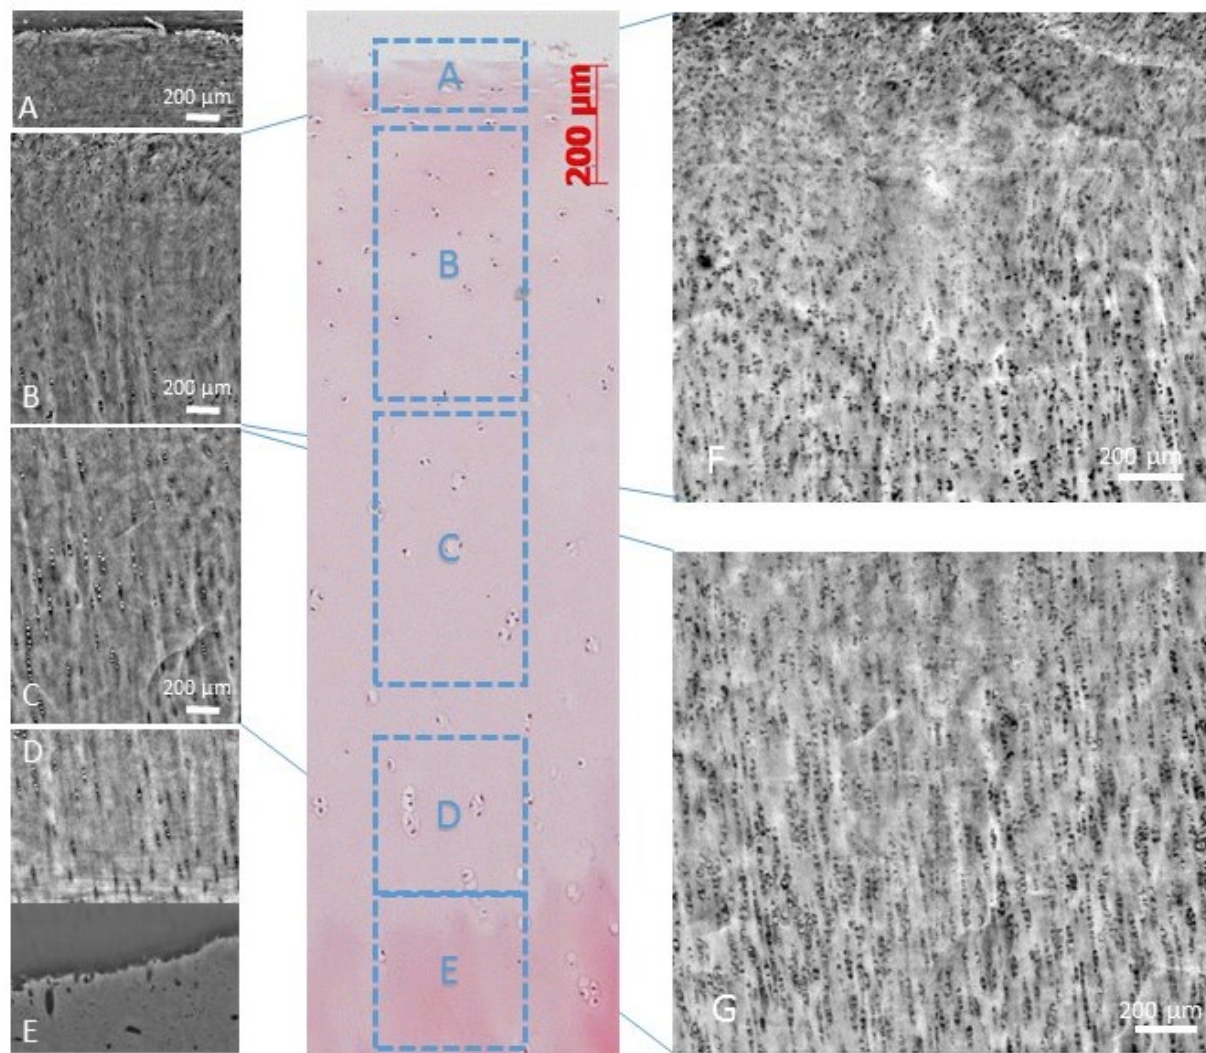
X-ray PCI sagittal images of healthy samples; the images come from ID17 with an effective pixel size of 0.7 µm; A)-D) four sagittal image of different cartilage zones. E) adjusted gray level for tidemark visualization F)+G) Z-projections from the mid zone, min values combined of 200 Slices H)-I) small healthy sample
